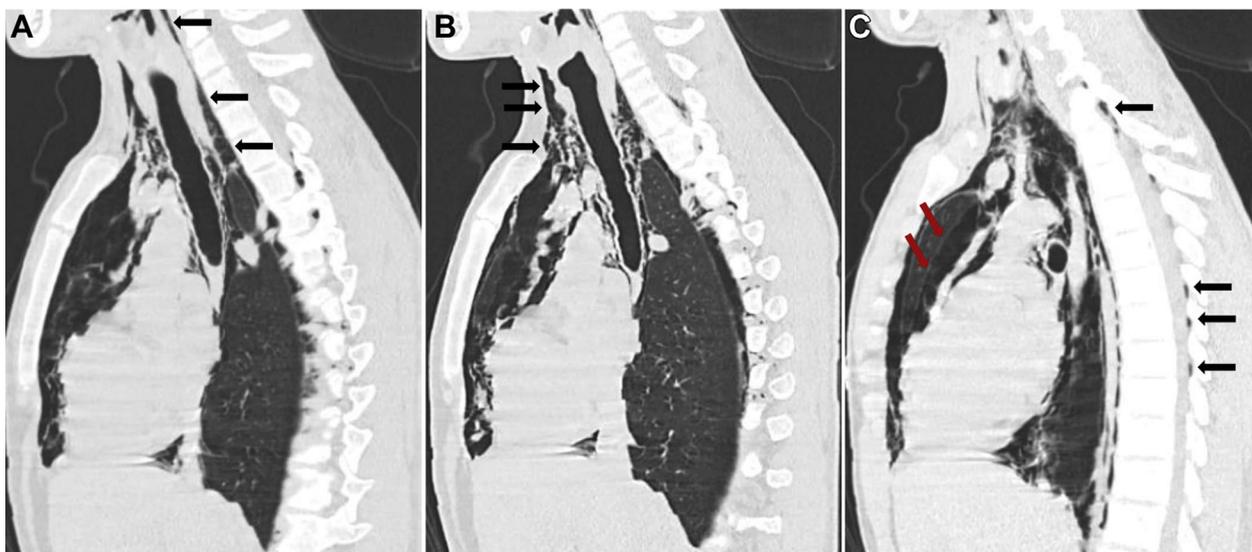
Sagittal view of CT scan of the neck and mediastinum. A, Extensive soft tissue abnormality (emphysema) in the retropharynx with loss of normal fat plane with the prevertebral space and possible communication with the oropharynx (black arrows). B, Air is also found in the pre-tracheal tissue (black arrows). C, Air extends into the mediastinum (red arrows). Noteworthy is the presence of the air bubbles from the sixth cervical vertebra until the ninth thoracic vertebra (black arrows).
